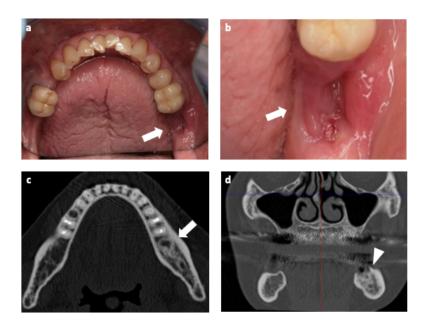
Stage 1, Focal MRONJ. Panel a: clinical view showing non healing post-extraction socket in the left posterior mandible (white arrow). Panel b: close-up view of the same lesion displays probing bone mucosal fistula (white arrow), gingival swelling and inflammation. Panel c and d: axial and coronal CT reconstructions show bone marrow sclerosis that is limited to the alveolar jawbone (white arrow and white arrow-head, respectively).
